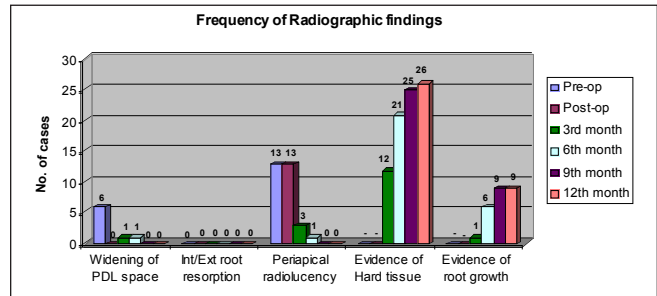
Graph showing the frequency of radiographic findings
